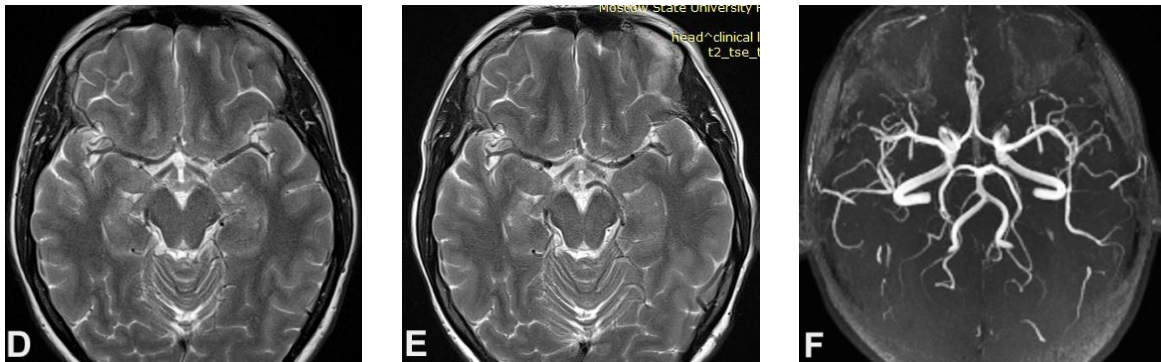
The same patient P., 34 years old, female (TDR-0): CT and MRI of the brain before and after transcatheter intracerebral laser PBMT.
